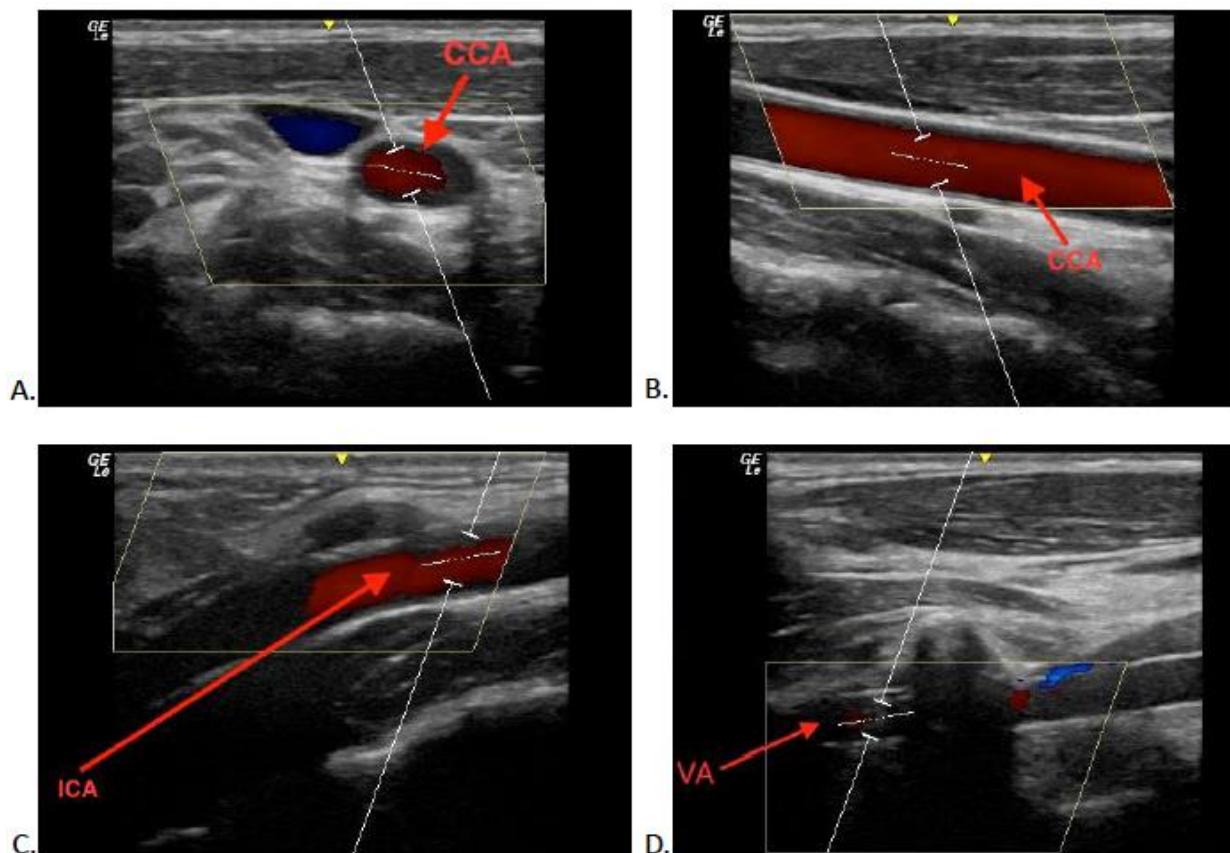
Doppler ultrasound imaging of the supplying vessels in the neck. A) Common carotid artery (CCA) in the transverse plane. B) CCA in the longitudinal plane C) Internal carotid artery (ICA) at level of bifurcation. D) Vertebral artery (VA) at level of intertransverse segments of the vertebrae.
